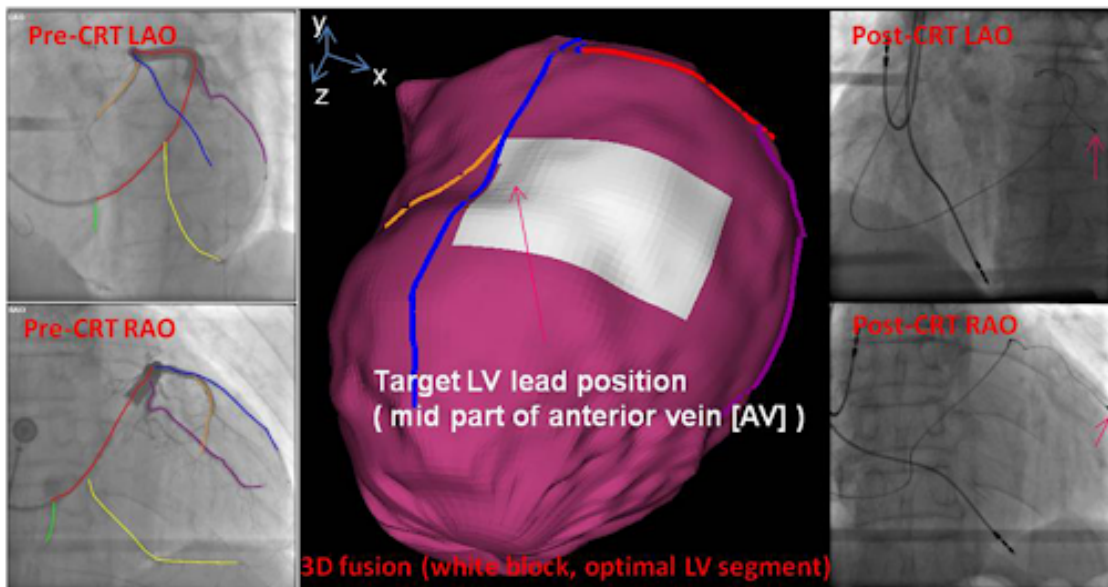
3D SPECT and fluoroscopy image fusion to guide the selection of target venous site and navigate the CRT left-ventricular lead placement [4]. The major veins were manually identified by operators on the pre-CRT fluoroscopic images, reconstructed to a 3D structure, and fused with SPECT MPI epicardial surface. The middle part of the anterior vein was the targeted LV lead position, which overlapped with the recommended LV lead segment (the white segment). The LV lead was placed under the guidance of this 3D fusion model to the target venous site (red arrows), as shown in the post-CRT fluoroscopy images. The QRS duration decreased from 168 to 140 ms immediately after the CRT device was turned on. After a 1-month follow-up, the LVEF increased from 32% to 57% assessed by echocardiography.
